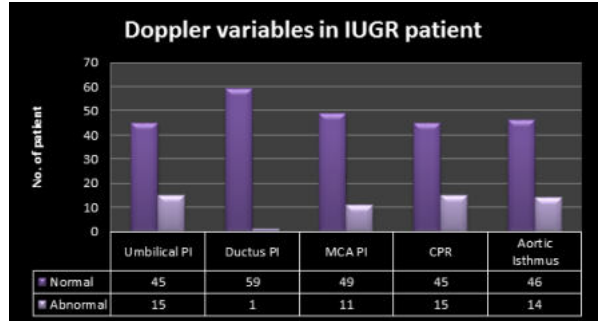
In present study, Doppler studies revealed that umbilical artery PI, ductus PI, MCA PI, CPR, and aortic isthmus PI waveforms were found to be abnormal in 25%, 1.66%, 18.33%, 25%, and 23.33% of the patients respectively.
